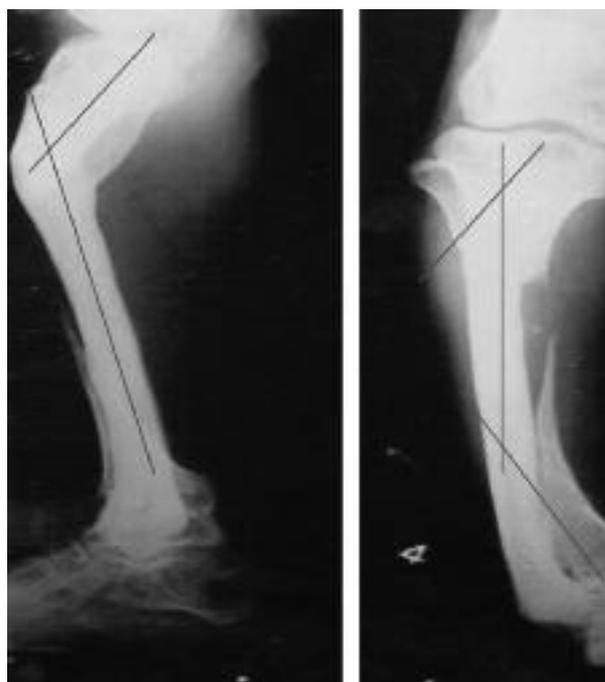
Preoperative radiograph of the patient showing deformity and two centers of rotation of angulations (CORA).
